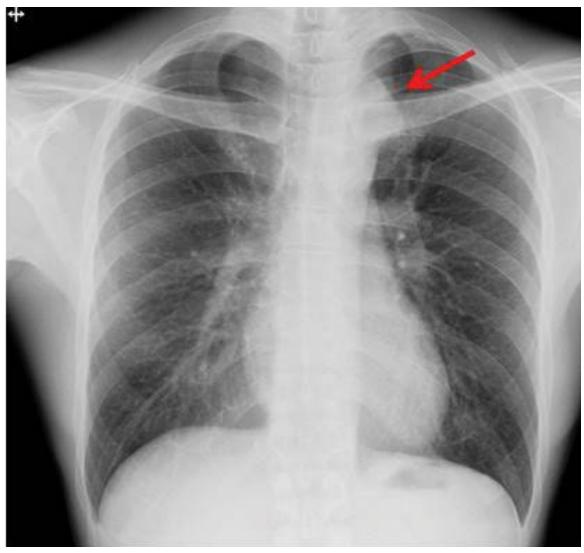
Chest X-ray showing a mass lesion (arrow) near the aortic arch in the left upper field.
